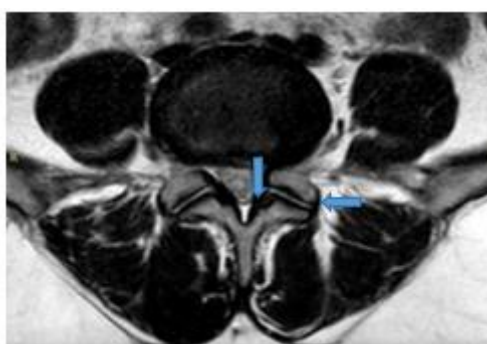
Axial plane of MRI showing, a left paramedian and foraminal disc protrusion at the L4–L5 level, obliterating the left lateral recess and contacting the exiting left L5 nerve root
